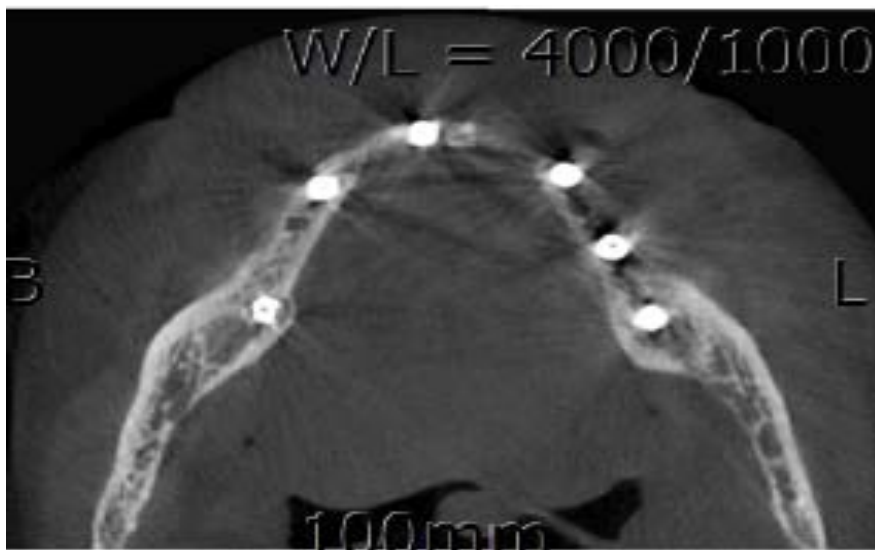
Showing the axial section of CBCT of mandible with osteograted implants.
